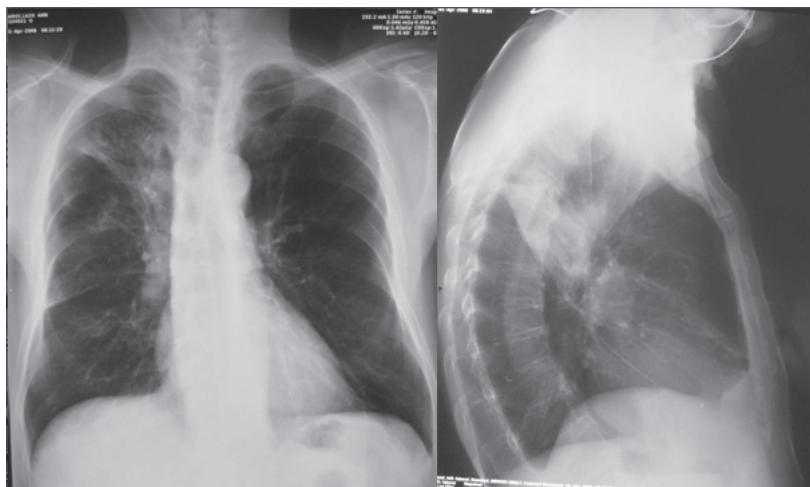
Posteroanterior and left lateral chest X-ray finding
